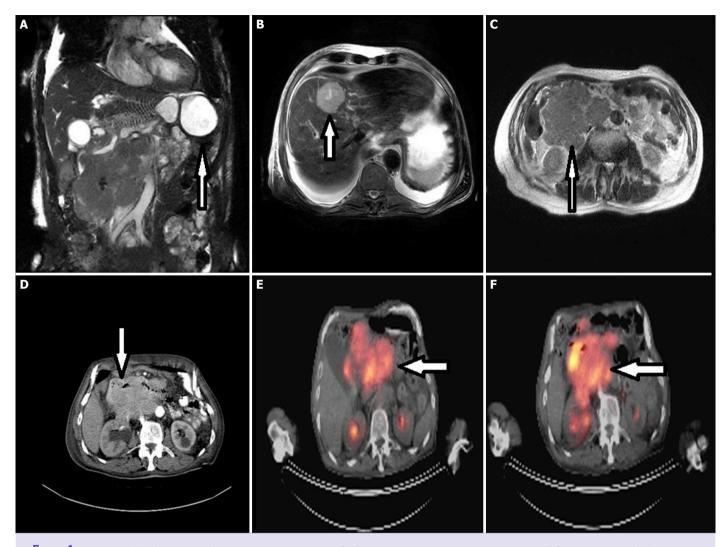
Patient 10 (malignant SPT) preoperative imaging, (A) MRI Cor Fiesta imaging, pancreas, (B) MRI T2-weighted imaging, Liver metastasis, (C) MRI T2-weighted imaging, liver metastasis, (D) CT imaging, pancreas, (E, F) PET-CT imaging.
